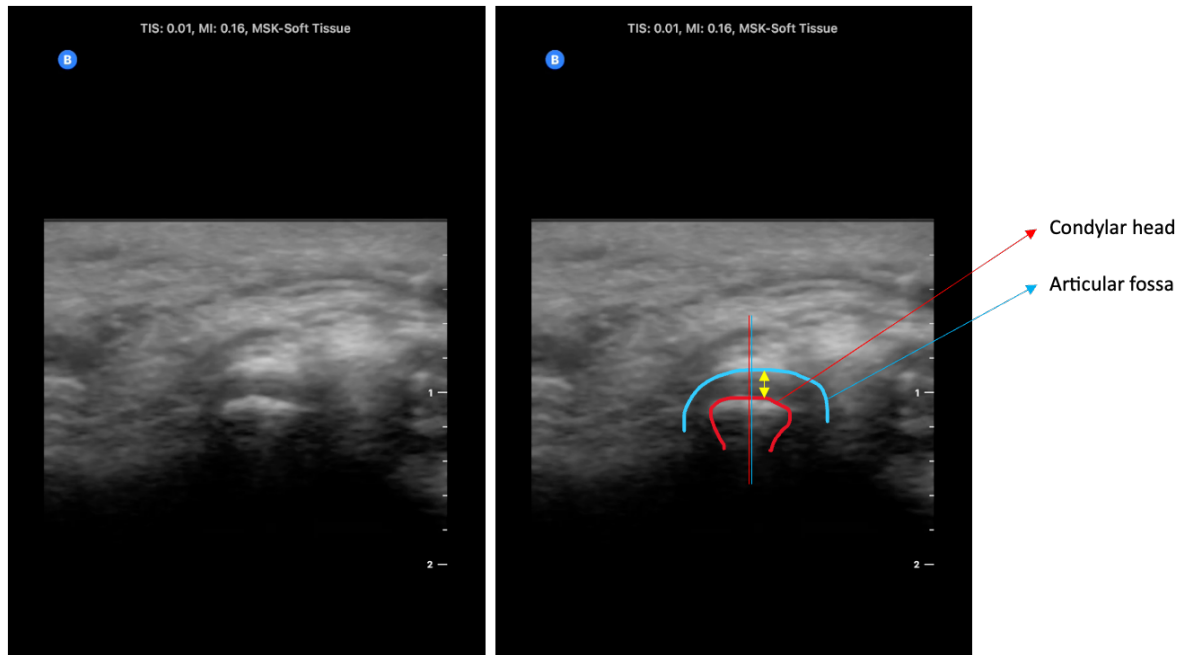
Ultrasound image of a normal joint. Ultrasound image of a normal joint in closed mouth position demonstrating patent joint space and centric positioning of the condyle within the glenoid fossa. Note that the red line corresponds to the centre of the condylar head and the blue line corresponds to the centre of the glenoid fossa, demonstrating that they are coincident. The yellow arrows indicate joint space.
